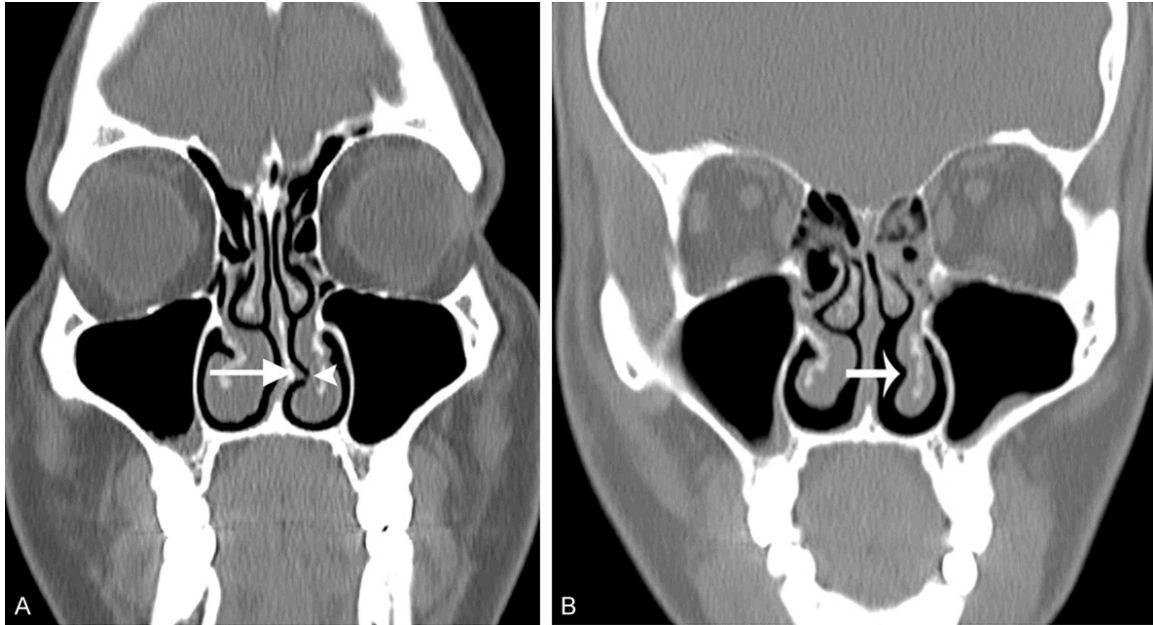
A. A 30 year-old male patient. Coronal CT multiplanar reformation image of paranasal sinus shows concha compression syndrome due to osseous spur which puts pressure on left inferior turbinate (arrow) and creates concha ondularis (arrowhead). B. Despite the disappearance of the concha compression, after 3 months preoperative symptoms occurring again 30 year old male patient; Coronal CT multiplanar reformation image of paranasal sinus after surgical removal of osseous spur demonstrates persistent left inferior concha ondularis (arrowhead) and bilateral rhinosinusitis symptoms.
